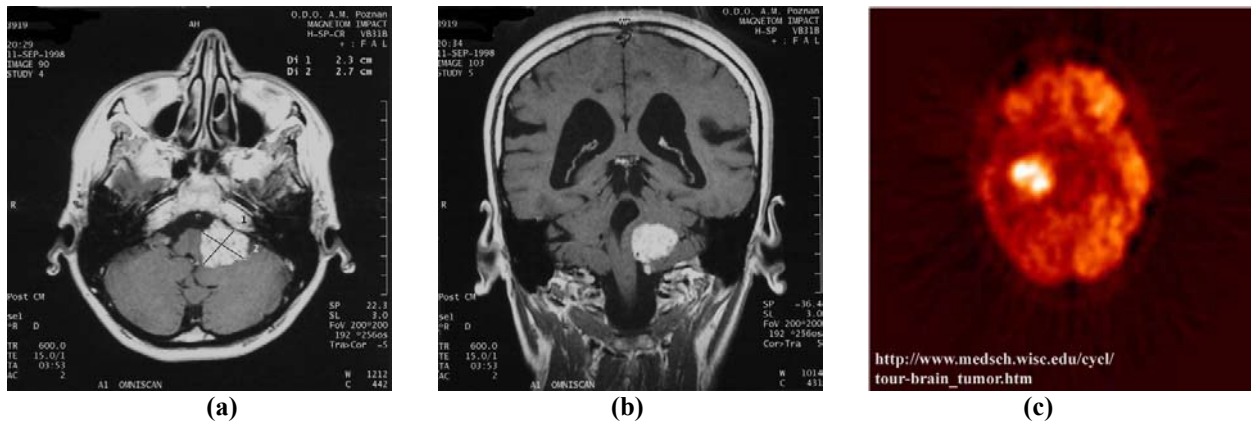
Example (a) x-ray CT, (b) MR, and (c) PET images of brain tumors. X-ray CT and MR images copied from <http://ampat.amu.edu.pl/przyp/case1/CASE1.HTM>.
